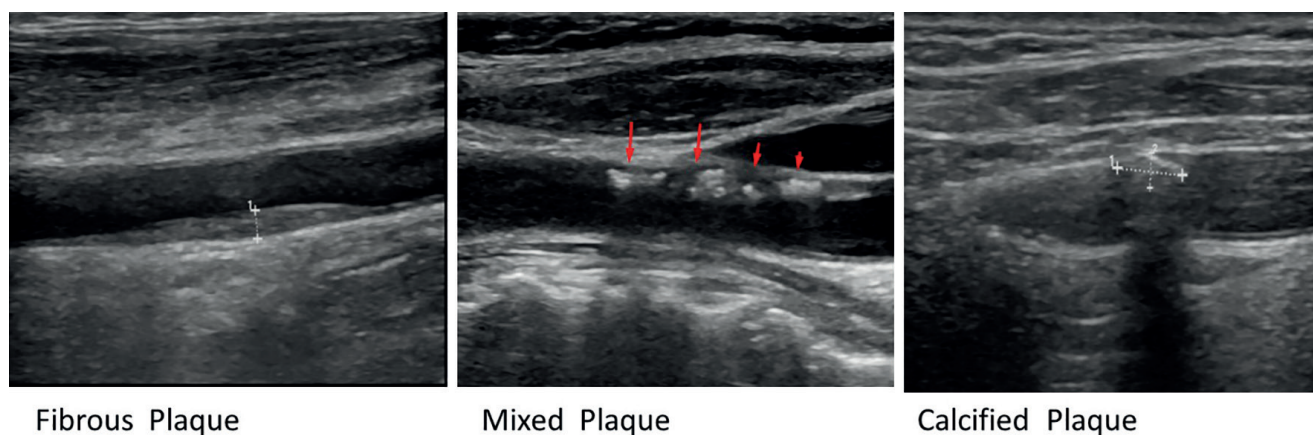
Types of carotid artery plaque on ultrasound.
